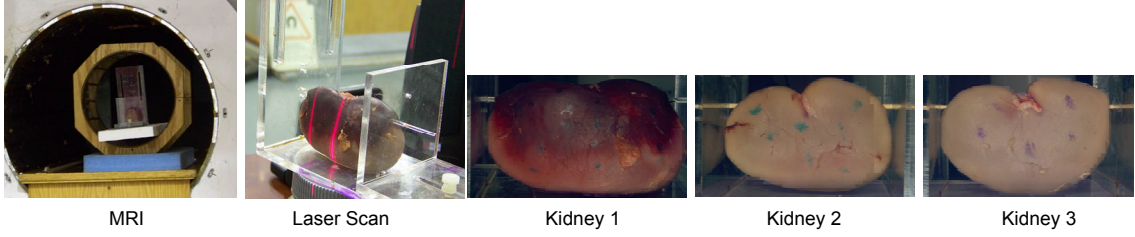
Experiment setup with MRI and laser scanner and three tested kidneys
